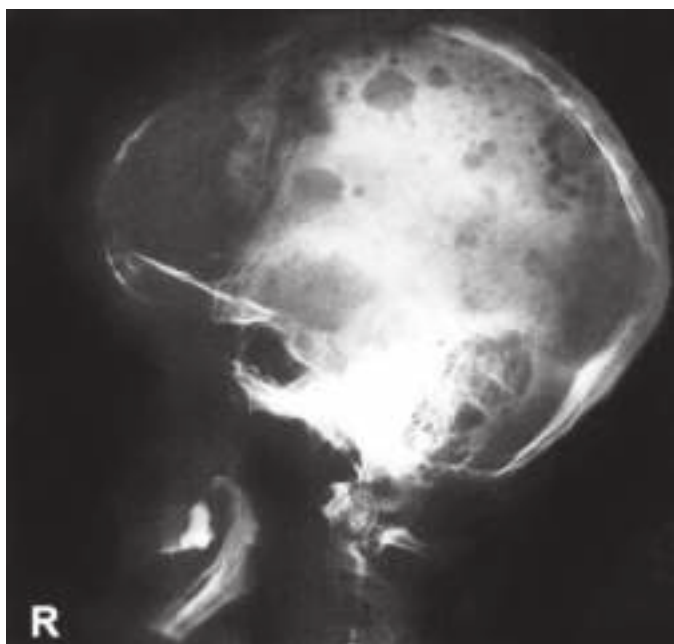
Radiograph of skull shows osteolytic lesion in a case of multiple myeloma. It shows multiple punched-out osteolytic lesions giving 'moth-eaten appearance'. Skeletal disease is one of the hallmarks of multiple myeloma. Osteolytic lesions begin in the medullary cavity, erode cancellous bone and progressively destroy the cortex. Bone lesions are associated with bone pain, pathologic fractures and hypercalcemia. Vertebral column is the most common site especially in lumbar regions. Osteolytic lesions affecting other bones in decreasing frequency include ribs, sternum, skull, pelvis, femur, clavicle and scapula. IgG and Bence-Jones myeloma produce osteolytic lesions.
